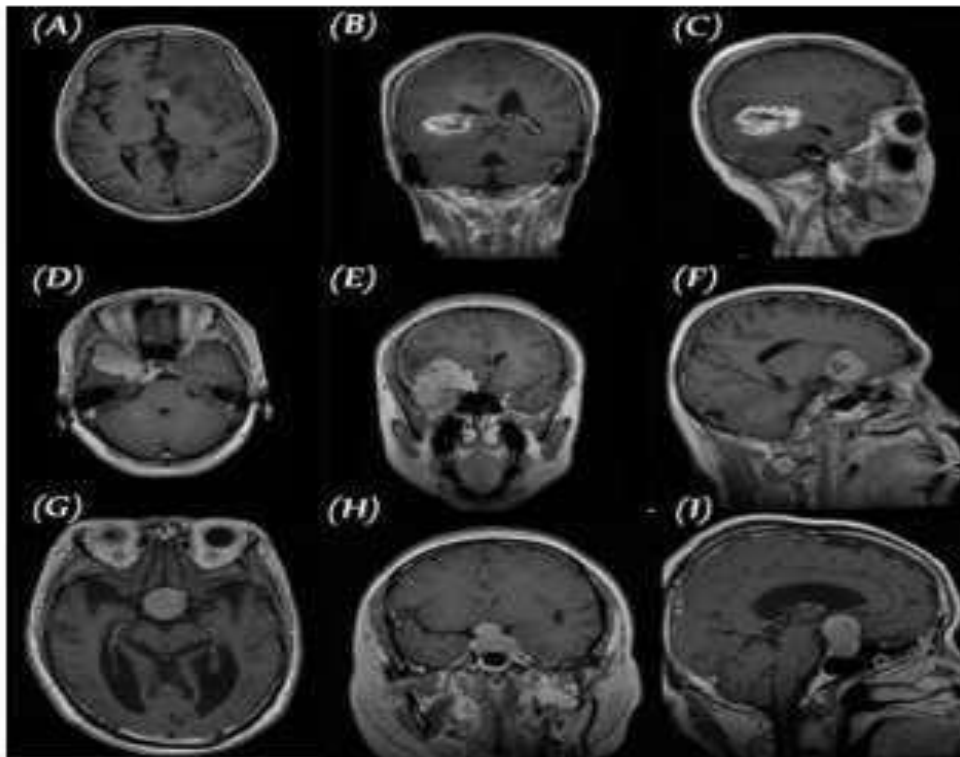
Three planes for three samples of brain tumor MR images from the primary data set, (A–C) glioma, (D–F) meningioma, and (G–I) pituitary.
